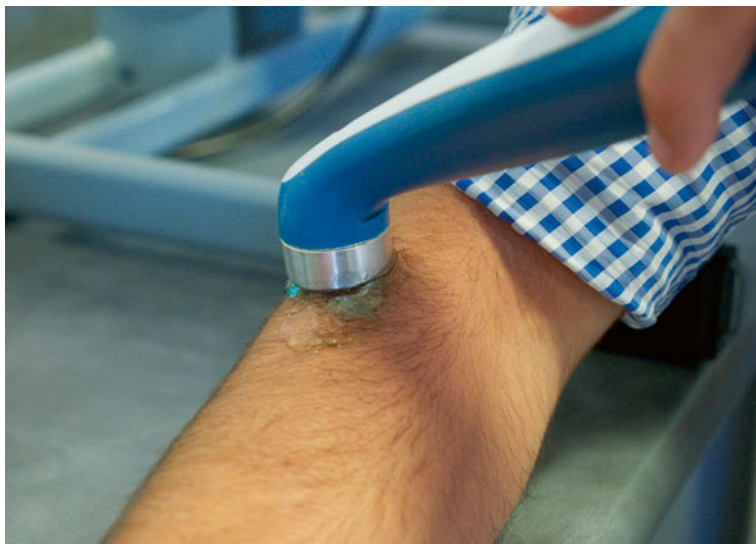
Ultrasounds on the area with fibrosis if the scar is closed
